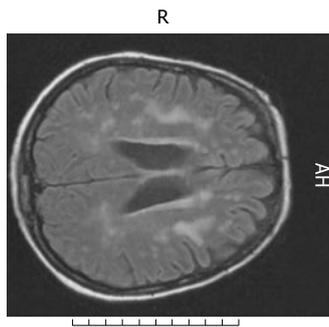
Magnetic resonance imaging (MRI) of the head showing almost symmetric periventricular white matter lesions consistent with leukoencephalopathy and a beginning encephalitis (FLAIR TR 8000 ms, TE 110 ms).
